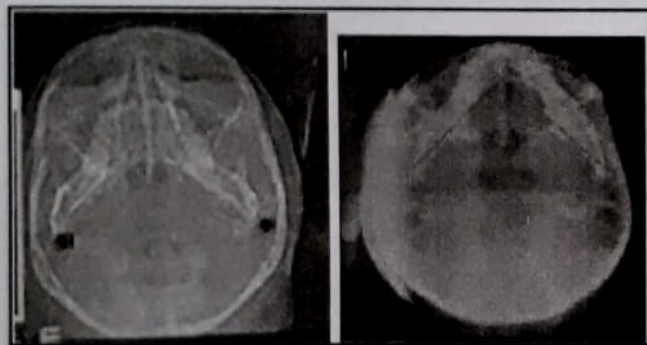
Measurement of mandibular body in CT and submental vertex ceph.
